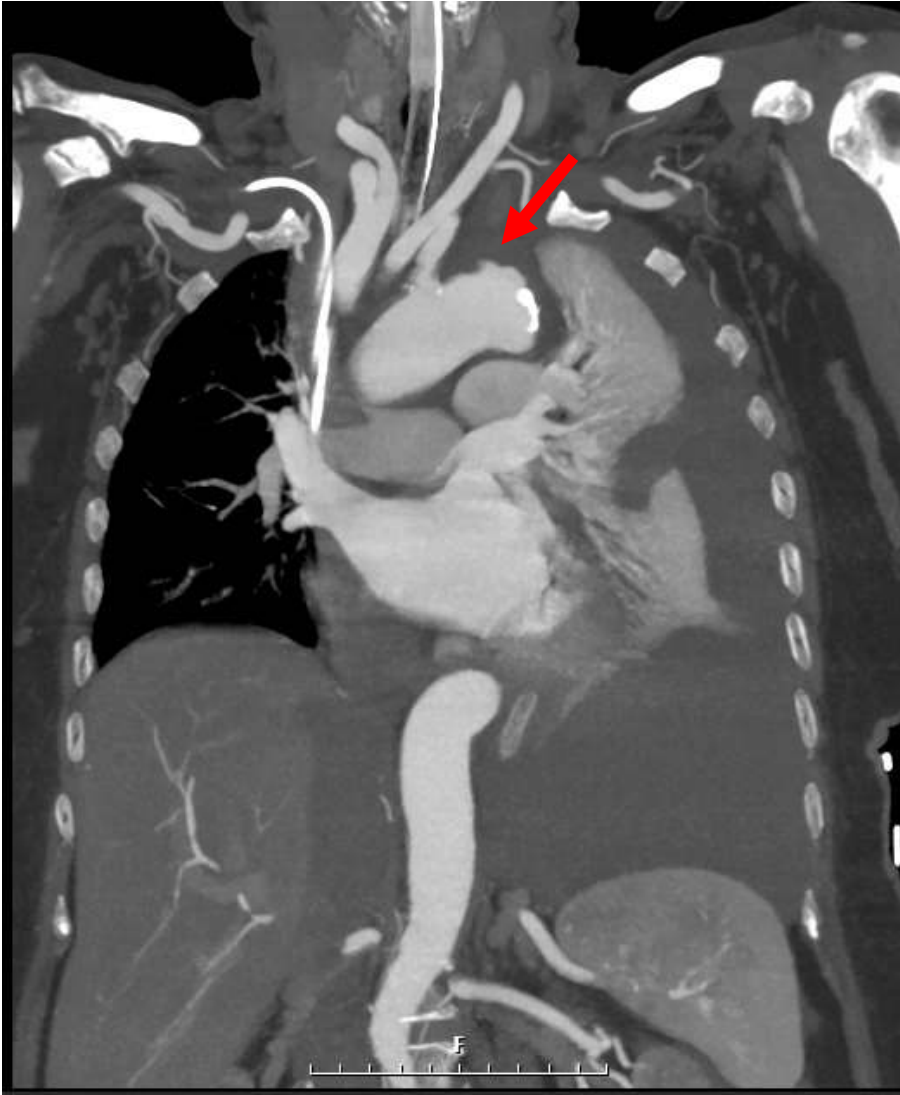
Computed tomographic angiography
